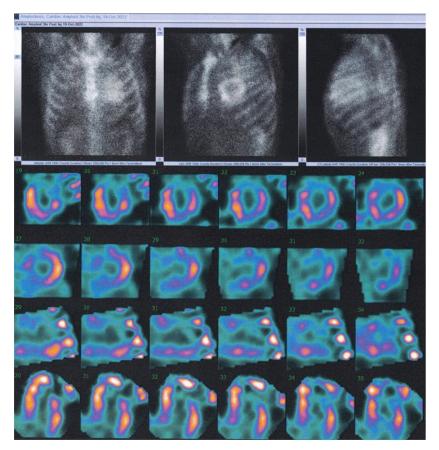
<sup>99m</sup>Tc-DPD scintigraphy: radiotracer uptake graded according to the Perugini score [29], Grade: III. Serum and urine-sample analysis revealed light chains, finding consisted with AL amyloidosis (source: Nuclear Medicine Department, Onassis Cardiac Surgery Cente).
